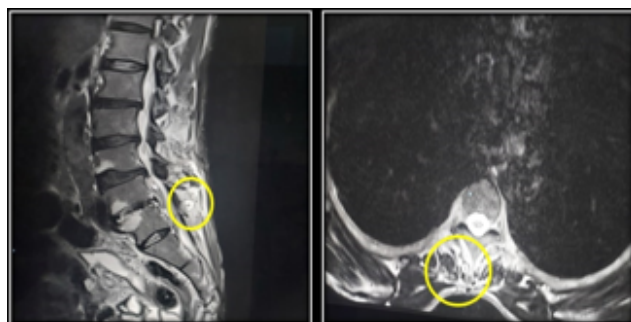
MRI scan of the spine showing ring enhancing lesions
